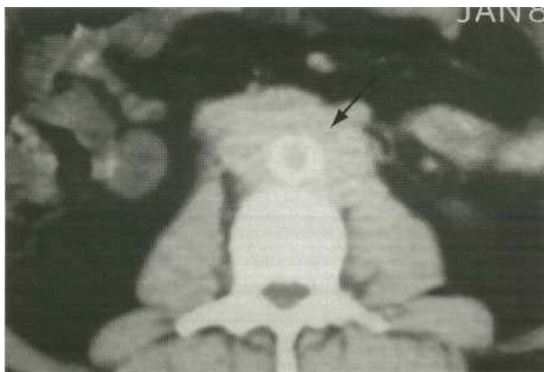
Retroperitoneal fibrosis (periaortitis). Note the large mass surrounding the abdominal aorta on this CT scan (arrow).
